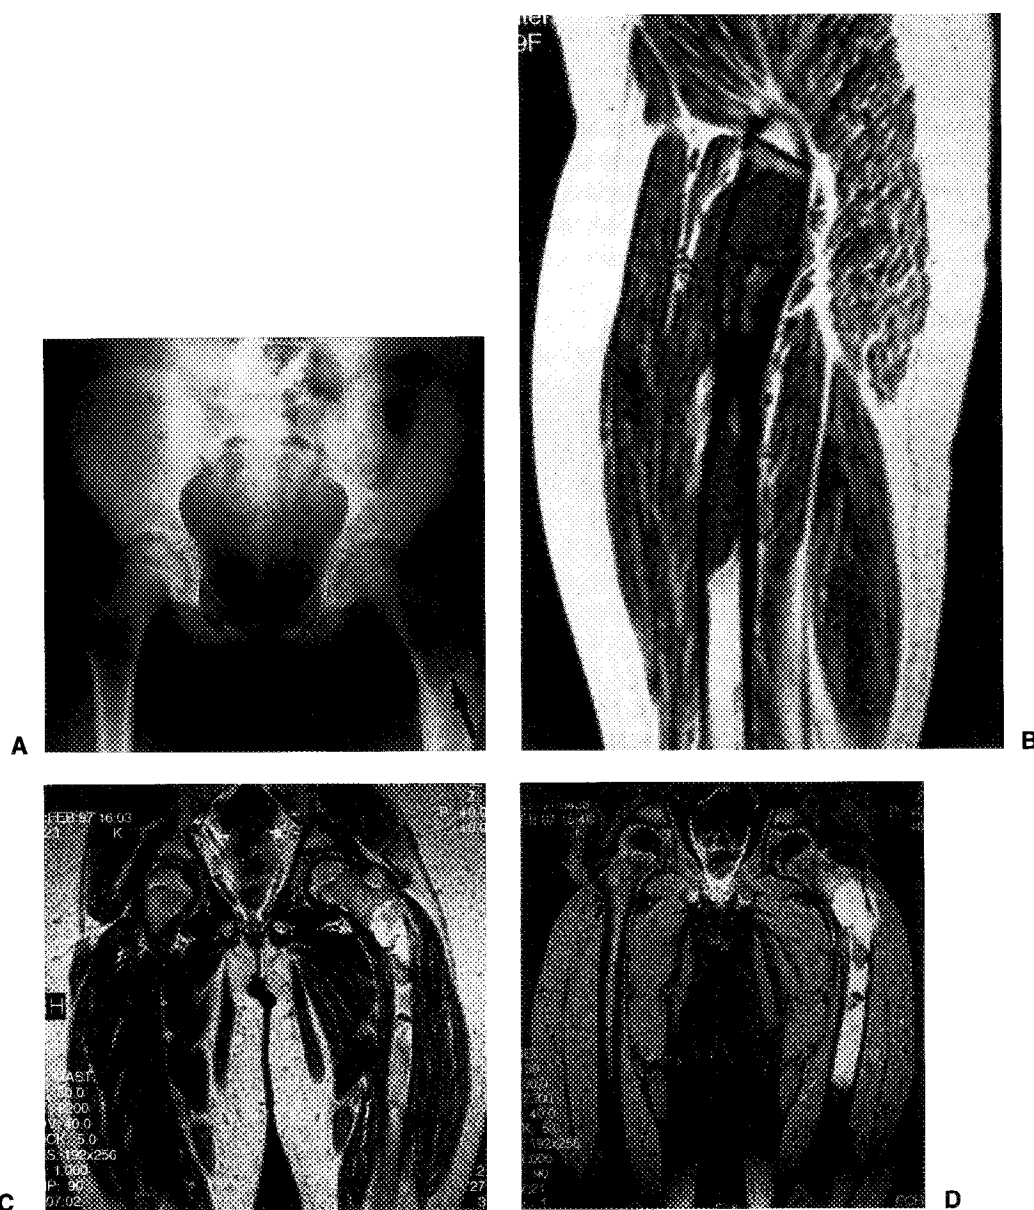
Fibrous dysplasia of the proximal femur in a 9-year-old girl. Anteroposterior pelvis radiograph (A) shows involvement of the proximal left femur (arrow) with a "shepherd's crook" deformity. Sagittal T1-weighted (500/16) MR image (B) shows the lesion extending through the proximal femur with a signal intensity similar to that of skeletal muscle. Coronal T2-weighted (2200/80) MR image (C) shows the lesion to have an intermediate signal intensity similar to that of fat, with some areas showing a signal intensity greater than that of fat. Corresponding STIR image (D, 2300/30/130) shows the lesion to have a high signal intensity.
